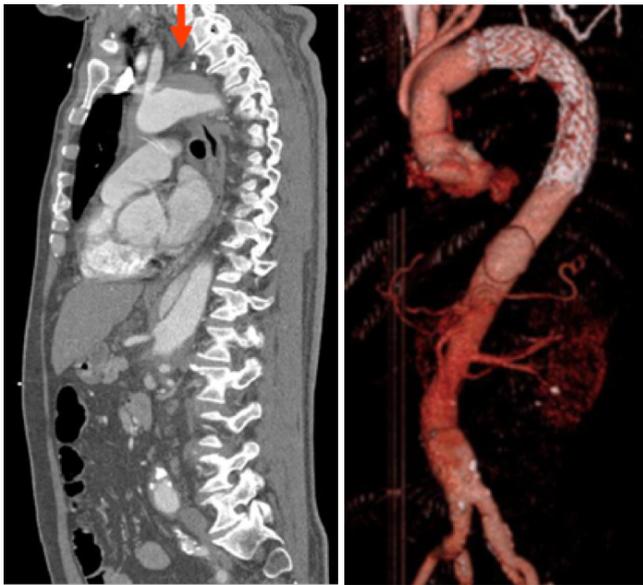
CT-imaging of a patient with retro-TAIMH in the arch. The red arrow shows the thicker section of the retro IMH located at the origin of the left common carotid artery. The patient was managed with ascending-arch repair and frozen elephant trunk. TAIMH, type A intramural hematoma.
